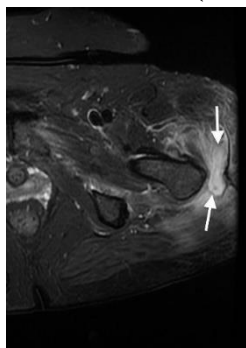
Transverse STIR image. Confirms that the abnormality on the T1-weighted image represents a fluid collection (arrows). There is florid oedema in the adjacent gluteal musculature, representing associated inflammatory change.
